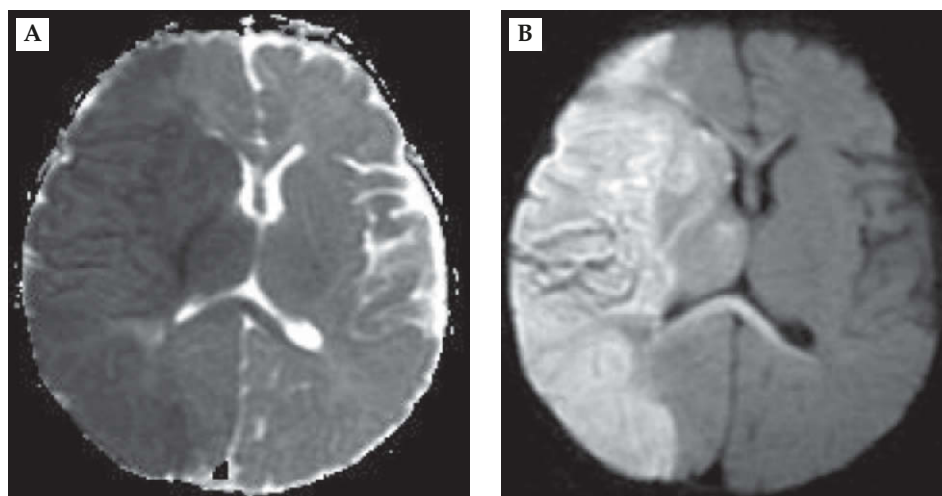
Age 3 months. (A) Apparent-diffusion-coefficient image and (B) diffusion-weighted axial magnetic resonance image demonstrated low and high signals in the right middle cerebral artery and partial posterior cerebral artery territory, with midline shift to the left side, which suggested acute infarction.
